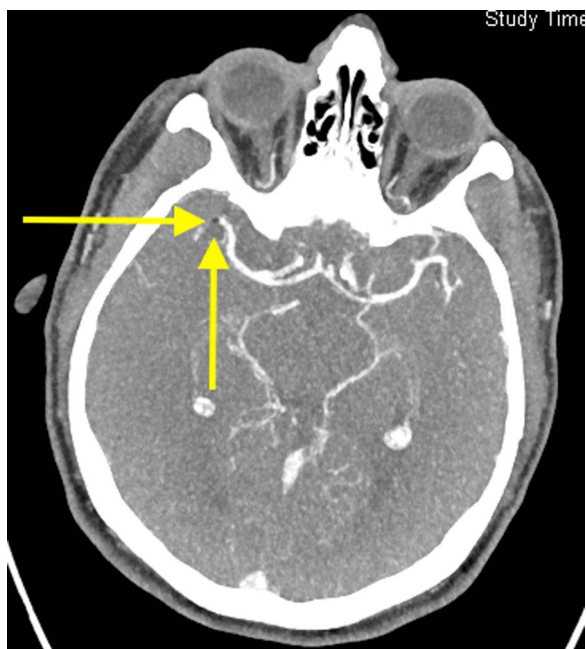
CT angiography showing air density material in the middle cerebral artery, superior division, with minimal filling past the stenosis (arrow).
